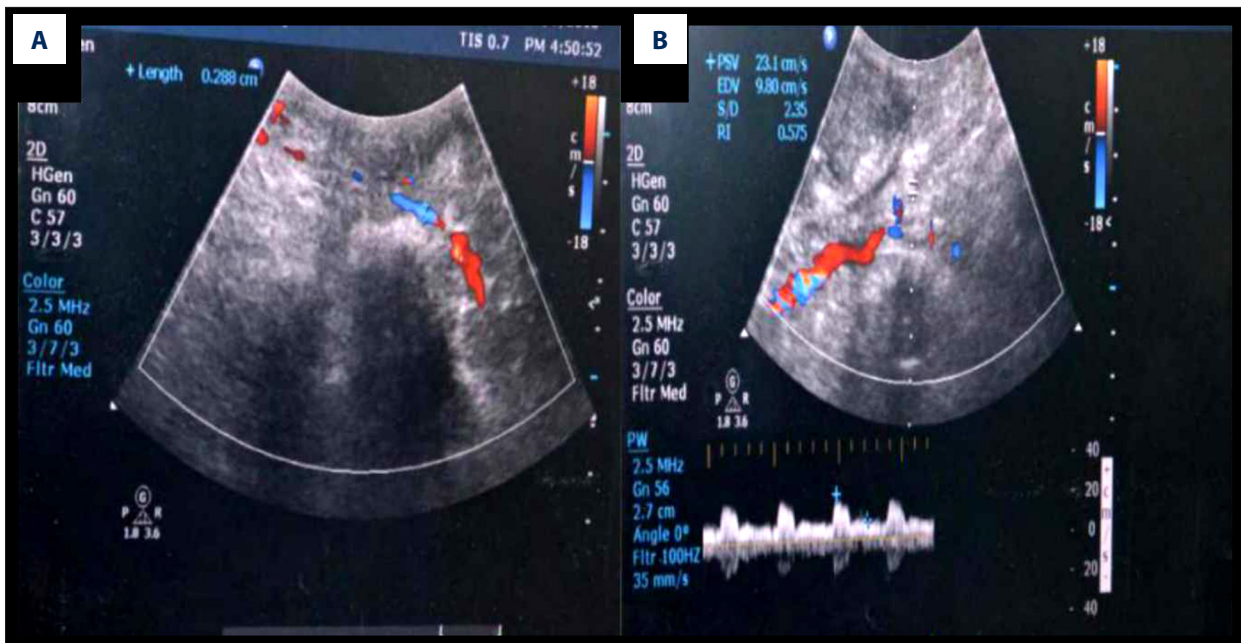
Doppler ultrasonography 1 week after UTx. flow resistance index (RI) on the right side: 28.8 cm/s (A); flow resistance index (RI) on the left side: 57 cm/s (B).
